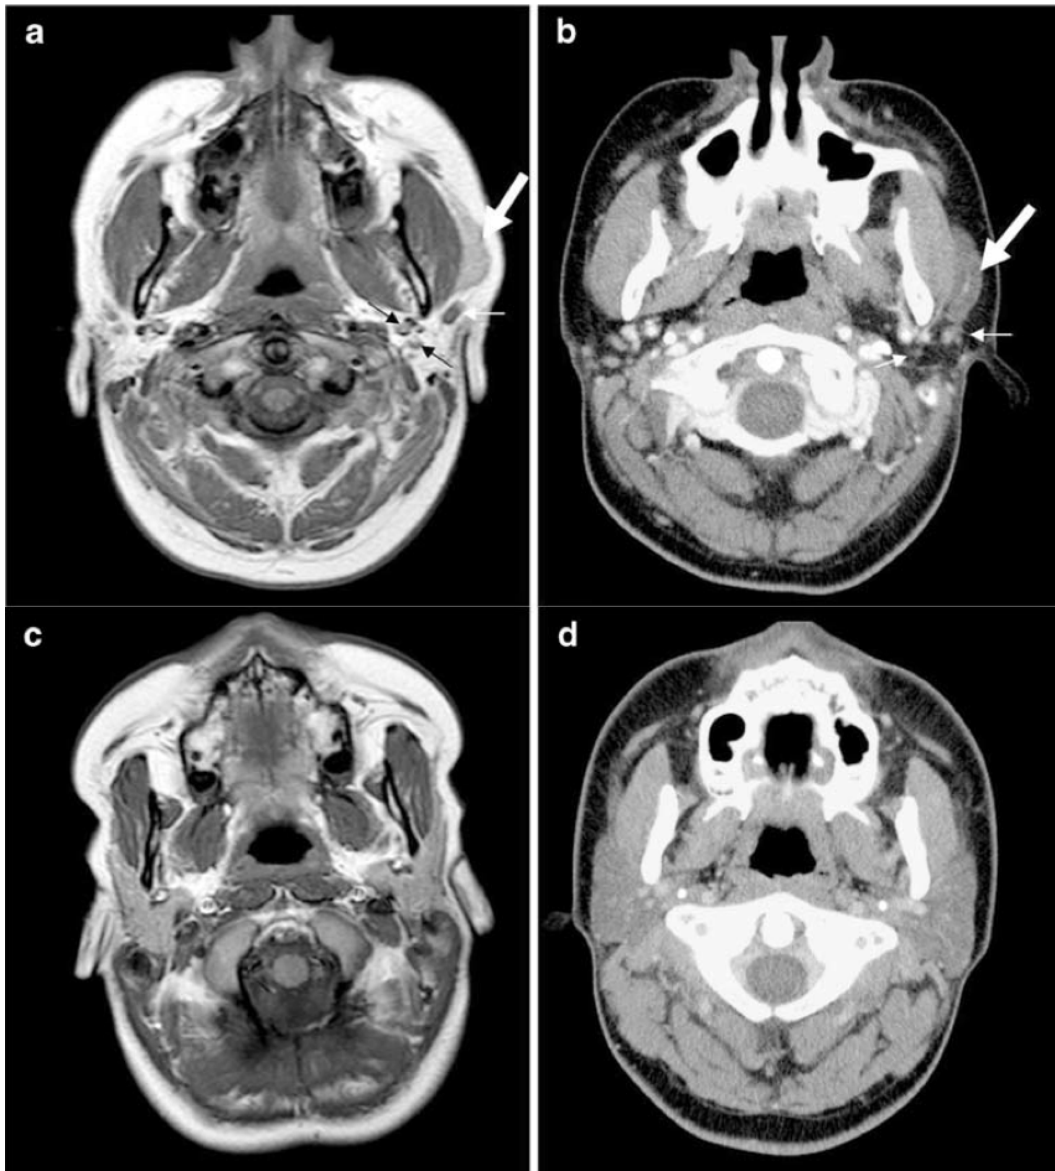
Axial MRI (a) and CT (b) images at the level of the angle of the mandible show bilateral absence of parotid glands with accessory parotid tissue on the left (large arrow). Within the parotid space, there is adipose tissue in addition to normal lymph nodes (small arrows) and vascular structures. Axial CT and MRI of a normal patient are shown for comparison (c, d)
